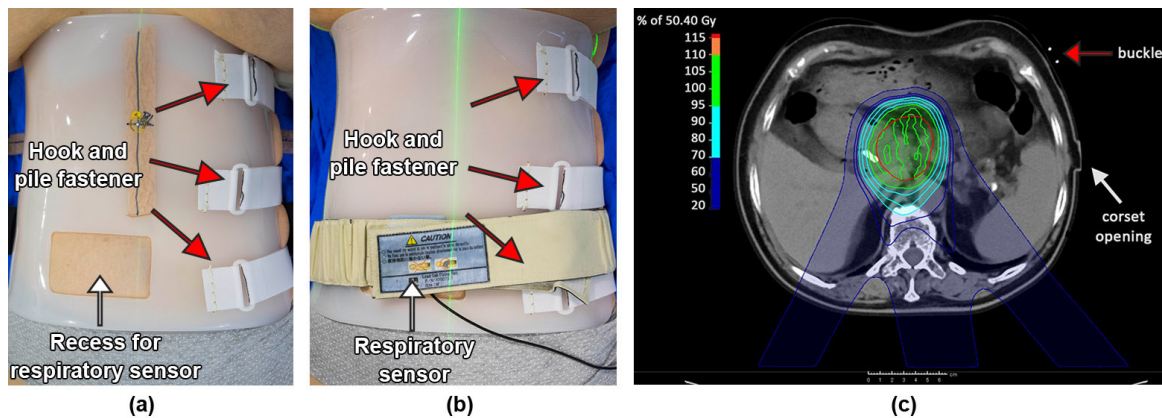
(a-b) Patient positioned in a vacuum mattress for acquisition of a 4D planning CT wearing the 3DPE corset. A recess (white arrow in (a)) is incorporated into the corset for positioning of a respiratory sensor (white arrow in (b)) for 4D CT reconstruction. (c) Example of a delivered proton therapy plan (robustly optimized scanned pencil beam) of a patient with a carcinoma of the pancreatic head wearing the 3DPE corset. Three beam angles were applied (140° , 170° , 208°) to accumulate a dose of 50.4 Gy within 28 fractions in the internal clinical target volume (red contour). The buckle of the corsets hook-and-pile fasteners and the corset opening are marked (red arrow in (c)). Beam angles penetrating these structures (40° – 100°) were avoided.
